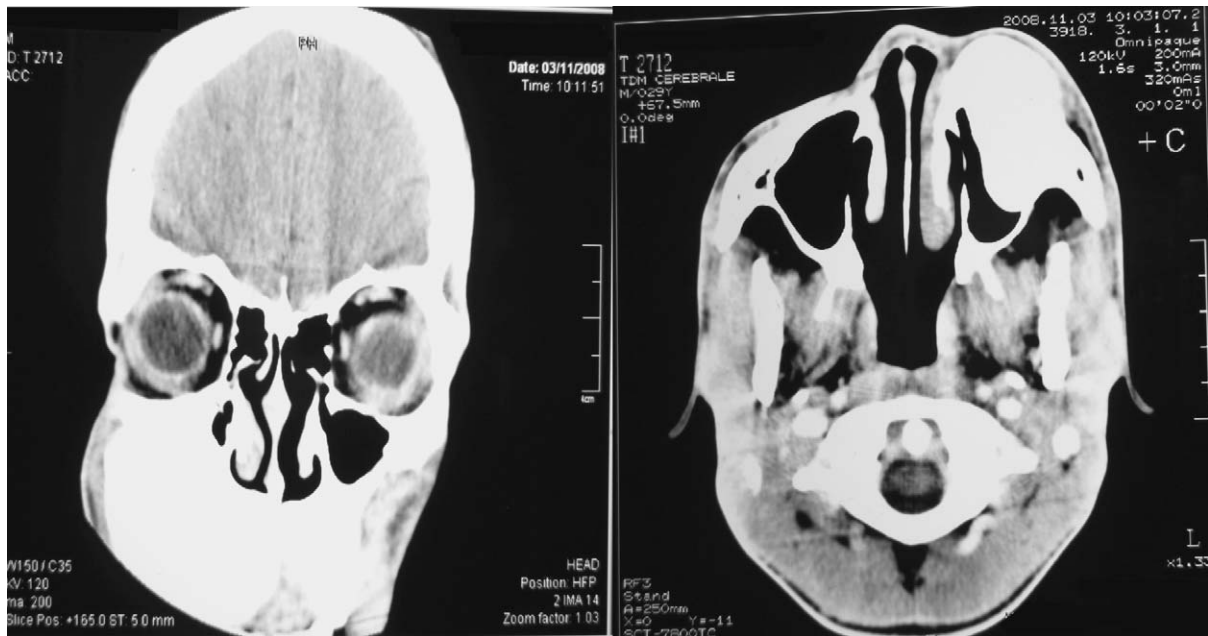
CT, coronal and axial views: the tumor mass occupying the entire left maxillary sinus pushing on the surrounding structures can be observed.
